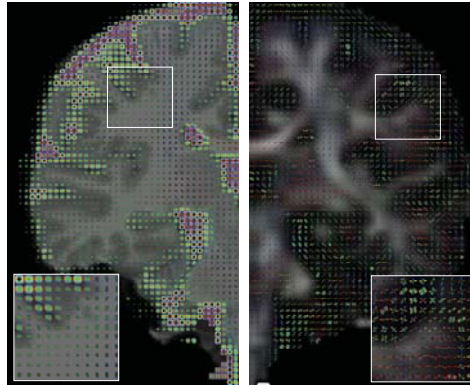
Whole brain coronal MRI view. *Left:* T1 MRI with diffusion tensors. *Right:* Fractional Anisotropy MRI with Persistent Angular Structure (PAS) reconstructions. Limited anisotropy is present in the gray matter (outside dark gray layer), resulting in isotropic diffusion tensors in the gray matter regions.
